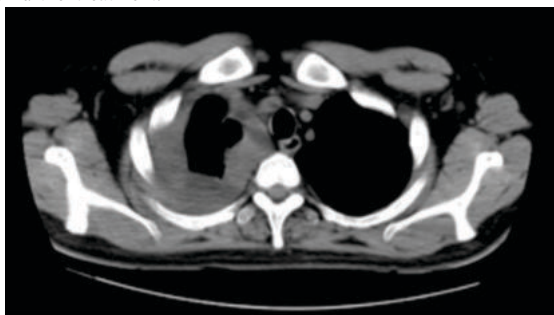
CT Chest Showing Right Anterolateral And Pretracheal Lobulated Mass.
